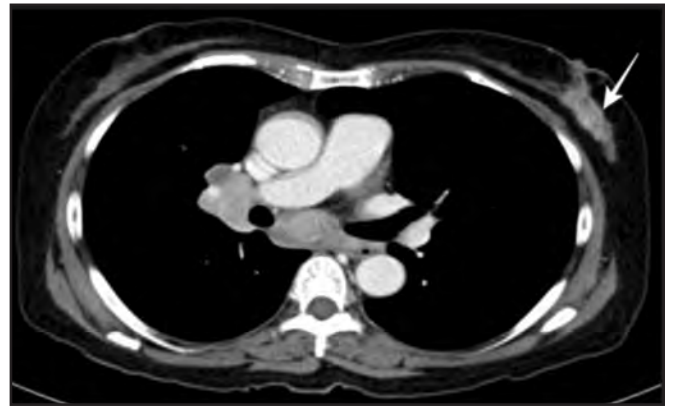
CT scan image. An ill-defined enhancing lesion at the outer quadrant of the left breast
